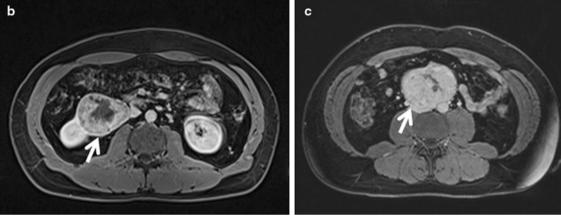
Images from whole-body MRI, white arrow points toward tumor. a 2.4 cm carotid body paraganglioma. b. 7.1 cm renal cell carcinoma. c 7.6×6.2 cm paraganglioma at the organ of zuckerkandl
